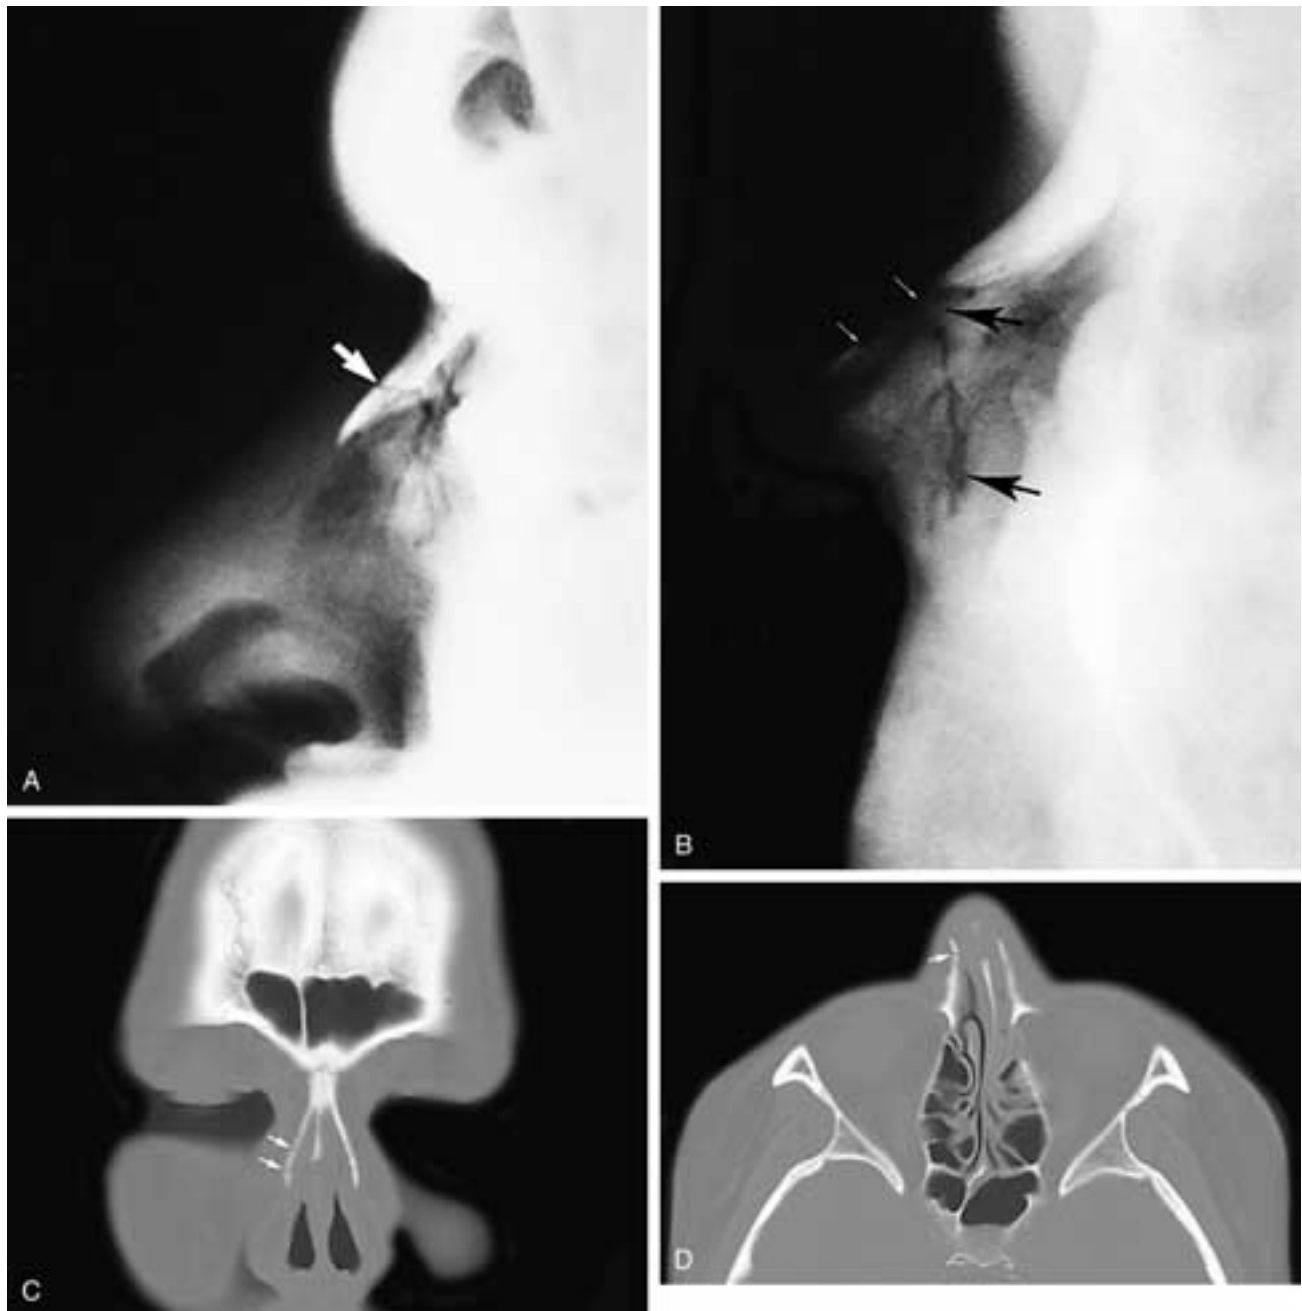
Lateral plain film (A) shows a nondisplaced fracture (*arrow*) extending from the midline nasal bones laterally. Lateral plain film (B) shows comminuted nasal bone fractures (*small arrows*) with extension into the frontal processes of the maxilla (*arrows*). Coronal (C) and axial (D) CT scans on another patient show minimally displaced right nasal fractures (*arrows*).
